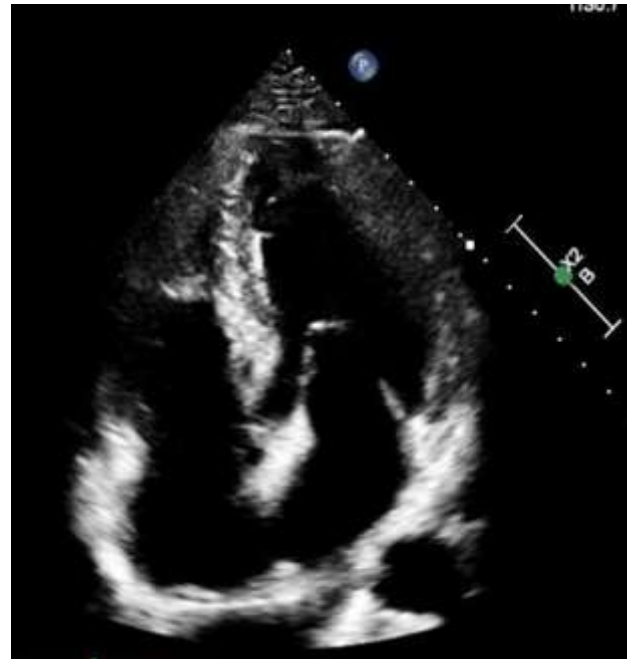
Echocardiogram (A4C view) of the patient: within the normal limits.
